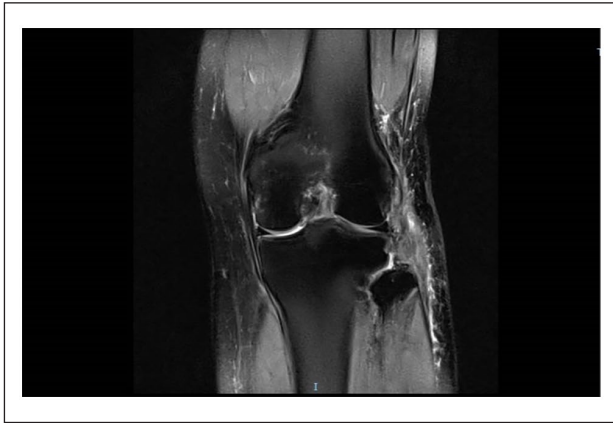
MRI showed an avulsion fracture of the fibular head of the left knee and a tear at the fibular insertion of collateral lateral ligament fibula of left knee.
